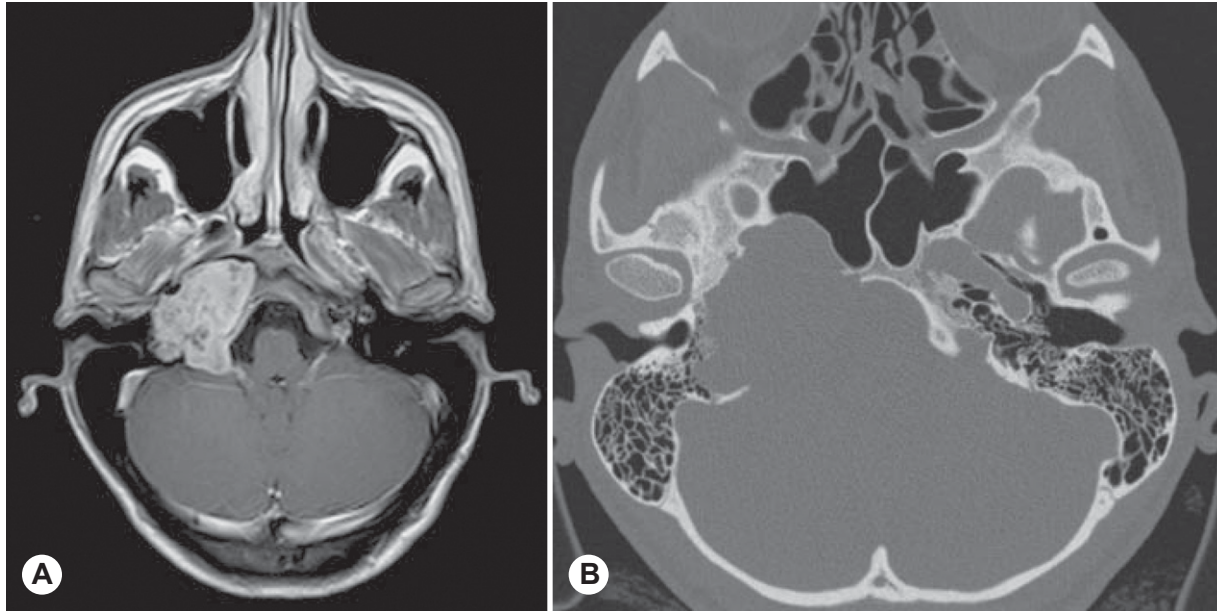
(Patient 10) A) Axial T1-weighted magnetic resonance image with gadolinium enhancement shows right petroclival chondrosarcoma. Tumor shows heterogeneous enhancement and appears to be confined to extradural space even though posterior cranial fossa dura is pushed medially. Internal carotid artery is encased by tumor and anteriorly displaced. B) Axial high-resolution computed tomographic scan with bone windows of same tumor shows irregular bone erosion of petrous apex and clivus.
